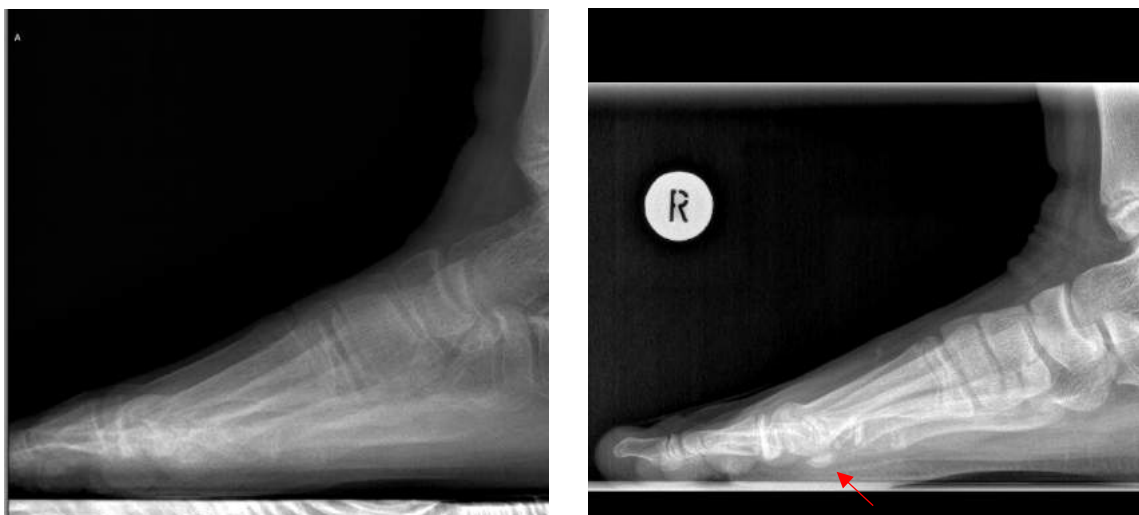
Lateral view of the foot in the same patient, taken with EOS (left) and conventional X-ray (right). While the plantar sesamoid was clearly visible on conventional X-ray (red arrow), due to overlap with the contralateral foot it was not clear on the EOS image. Images were taken within 24 hours of each other.
